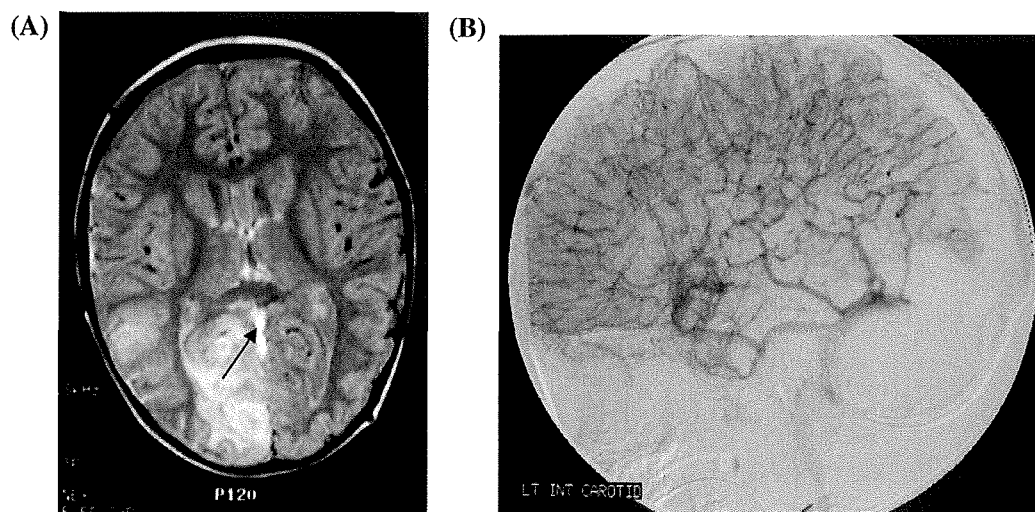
Neuroimaging from a 22-month-old boy with iron deficiency anaemia. (A) MRI showing that the abnormal high signal involves predominantly the right occipital lobe. The straight sinus is occluded; subacute thrombus is seen as high signal on proton density images (arrow). (B) Five months later the venous phase of the cerebral angiogram demonstrates absence of flow in the occluded superior sagittal and straight sinus. Multiple collateral vessels drain the hemisphere towards the cavernous sinus.
